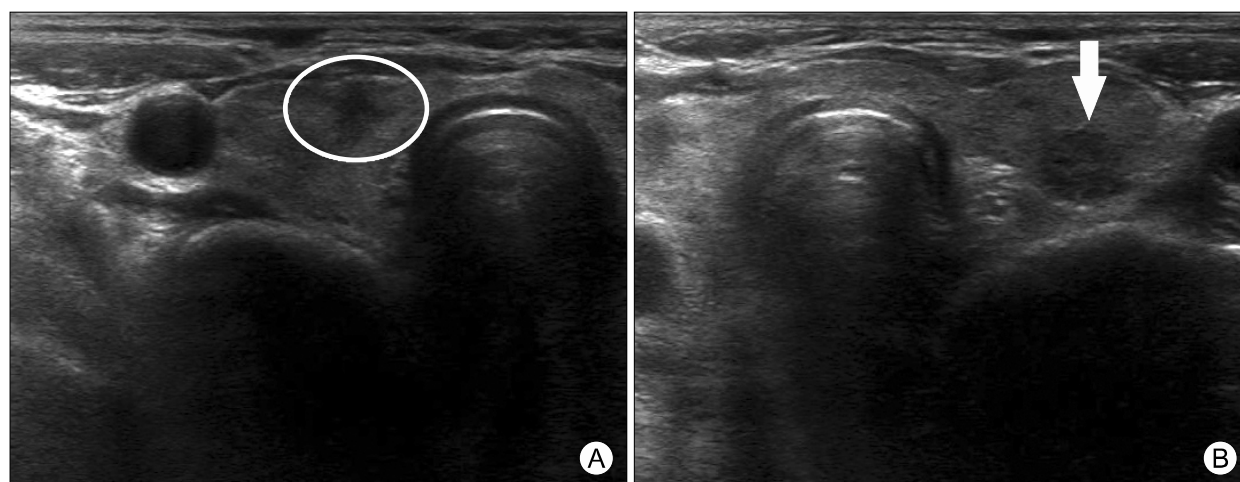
Ultrasonography for the thyroid gland revealed the diffuse enlarged left lobe of the thyroid gland with 0.8 cm size of hypoechoic nodule (arrow) whereas about 0.5 cm size of irregular shaped hypoechoic nodule found near the right side of the isthmus (circle).
